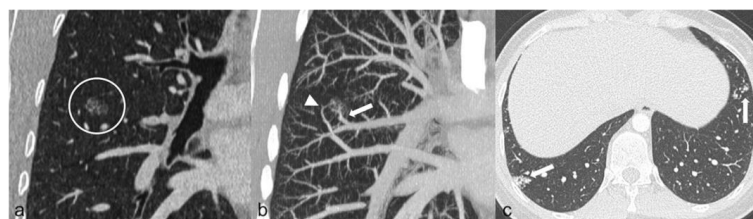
(a) Coronal CT-scan image showing the presence of a 23 mm (circle) nodule with well-defined margins and a “ground-glass” appearance. (b) Maximum intensity projection clearly shows the artery feeding (arrows) and veins (arrows) of the PAVM. (c) The presence of multiple simple PAVMs (arrows) in the lower lobes strengthens the presumptive diagnosis.
